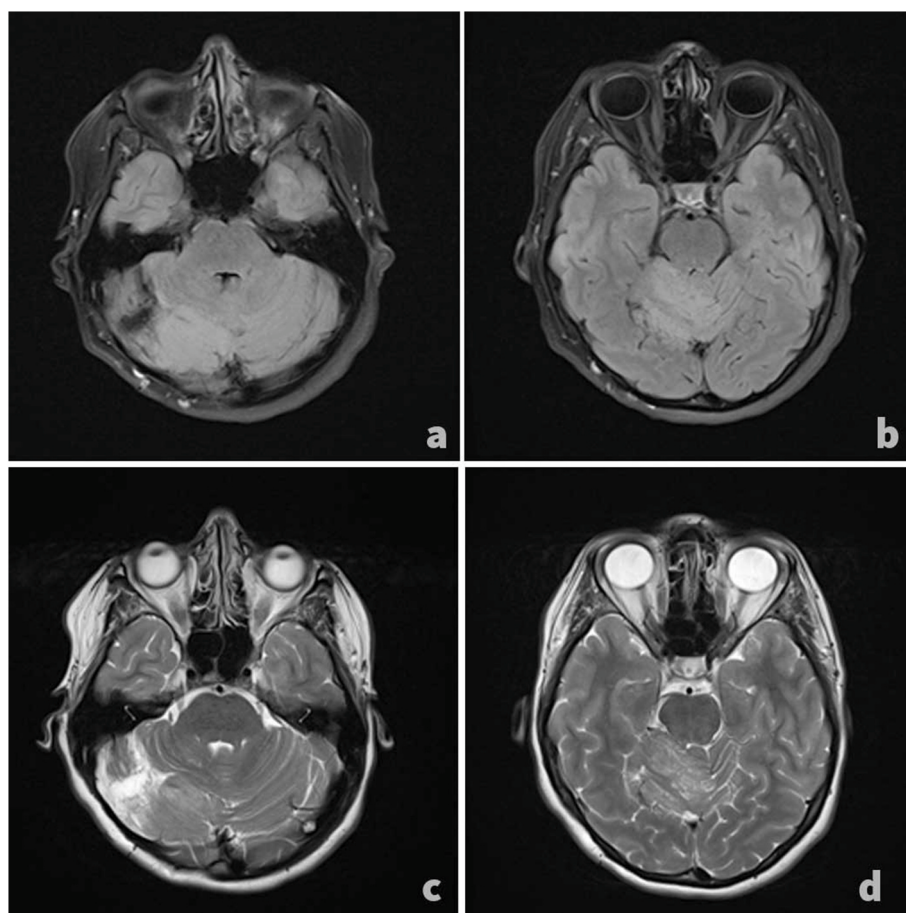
Immediate postoperative T-2 and FLAIR-weighted MRI scans in axial reformation revealed a residue of the tumor process in the right cerebellar hemisphere and the mediocranial vermis (a, b). No further tumor recurrence was revealed on axial T-2 weighted MRI scans at a two-year checkup (c, d).
